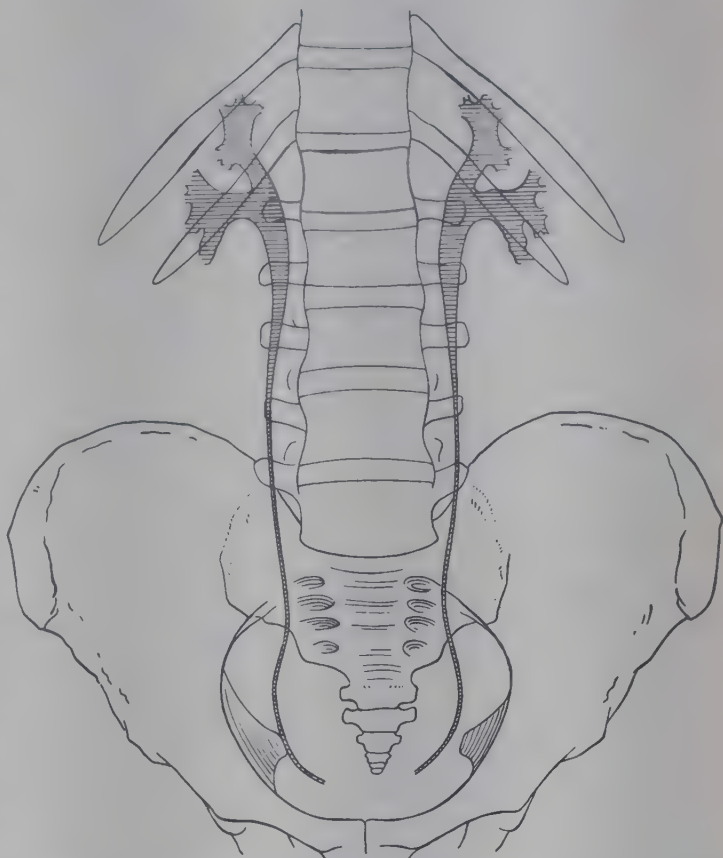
OUTLINES OF Pelves OF URETERS AND OF URETERS PROPER IN RELATION TO THE SKELETON. (Drawn from radiograph; cf. Pls. LXX, LXXI, p. 744.)
